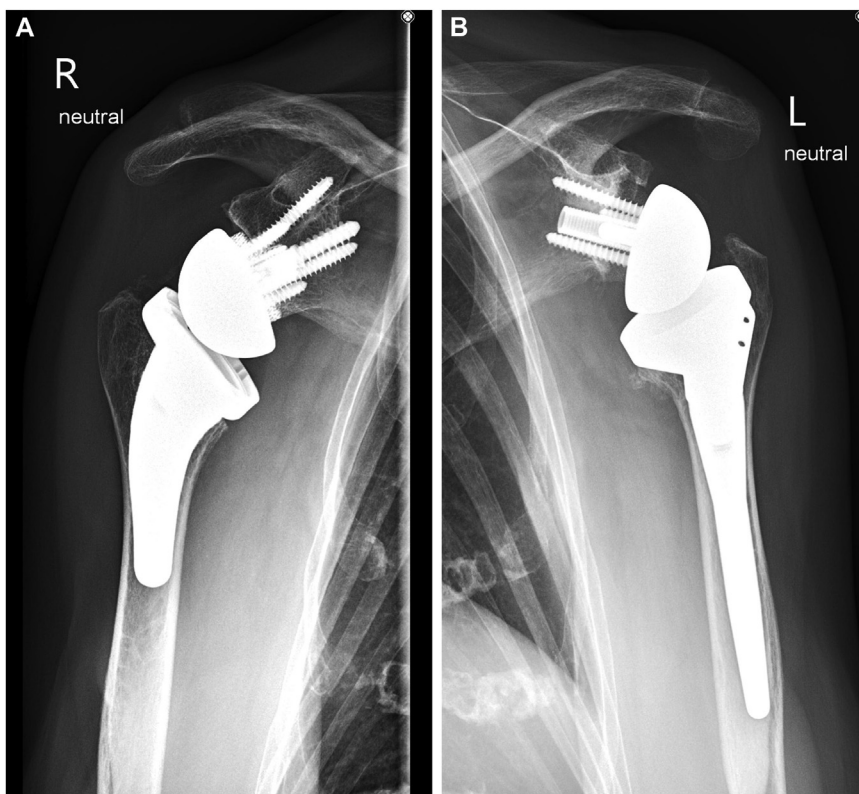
Anteroposterior radiograph of the (A) right shoulder and the (B) left shoulder obtained at the 8-week office follow-up showing consolidation of the glenoid bone graft with well-positioned humeral and glenoid implants.
